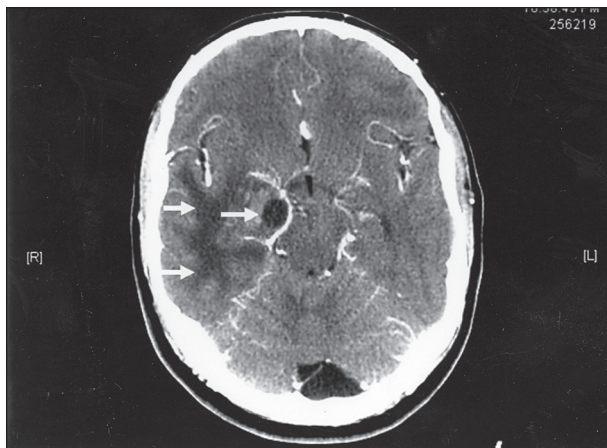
CT brain, post-contrast showing cystic lesion in the right temporal lobe, just lateral to the right cerebral peduncle with adjacent enhancing nodules surrounded by vasogenic edema
